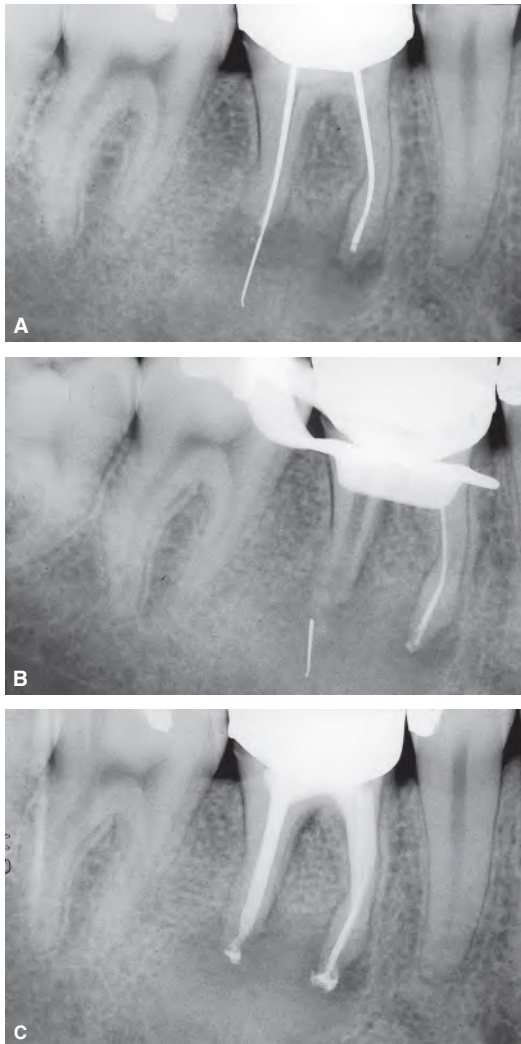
A silver cone is grossly extruding beyond the apex. It has become corroded, causing a separation of the cone into two segments at the level of the apical foramen. A. Preoperative radiograph. B. The silver cone has been removed from the distal canal, but the segment beyond the apex has remained. The patient developed an abscess that was left to drain from the tooth. C. One week postoperative radiograph after obturation. The silver cone fragment was “drained” externally, together with the purulent exudate.
